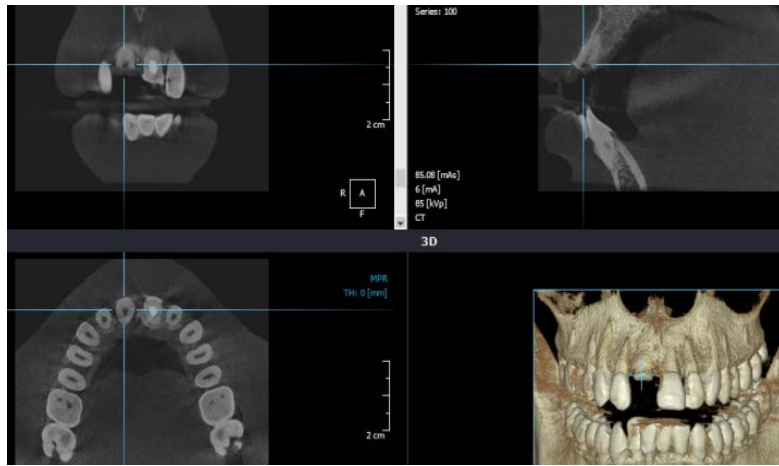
Cone-beam computed tomography (CBCT).
